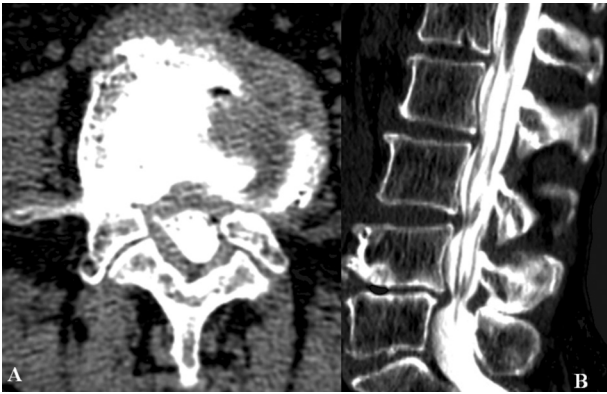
CT-assisted myelography: (A) axial view at L₄₋₅ level; (B) sagittal reconstruction — degenerative stenosis at L₄₋₅ level
